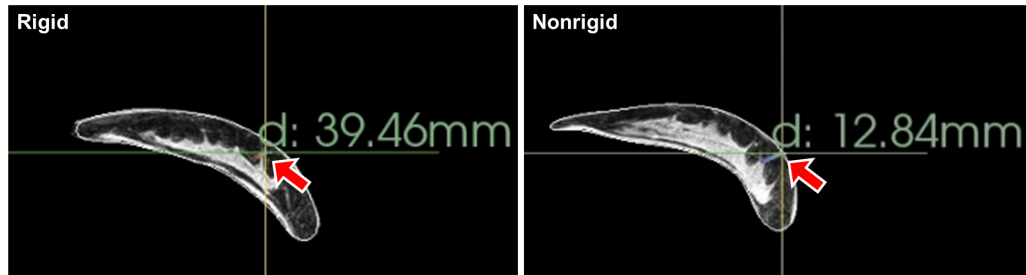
Guidance system axial MR imaging views before deformation correction (left) and after deformation correction (right).
